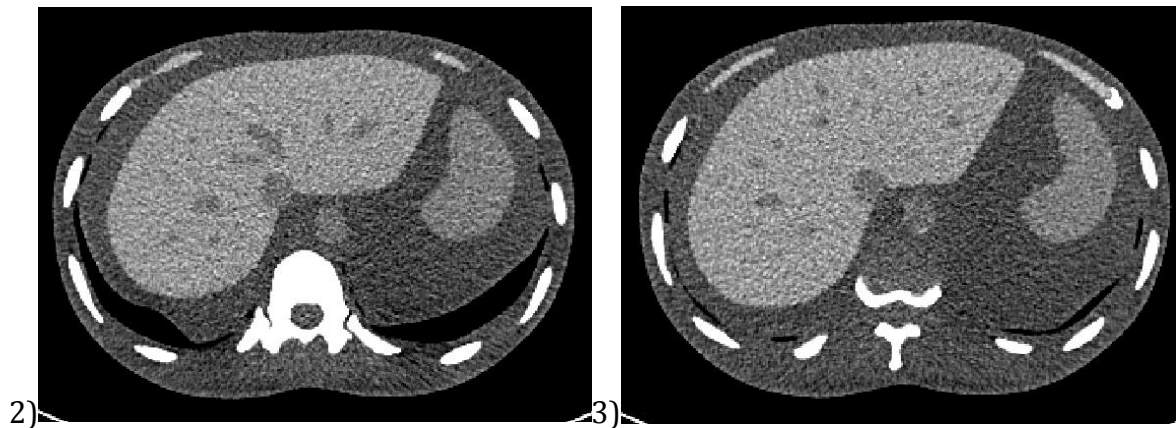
i) A sketch of the liver and its' veins (Merran and Dixon 1991). The three different levels has been marked as 1, 2 and 3. Moving down in the liver, the vessels move outwards and become thinner. How far out these vessels were visible where used as an image quality criteria. The CT images are from the reference setting of 240 mAs, filter I30_1.
